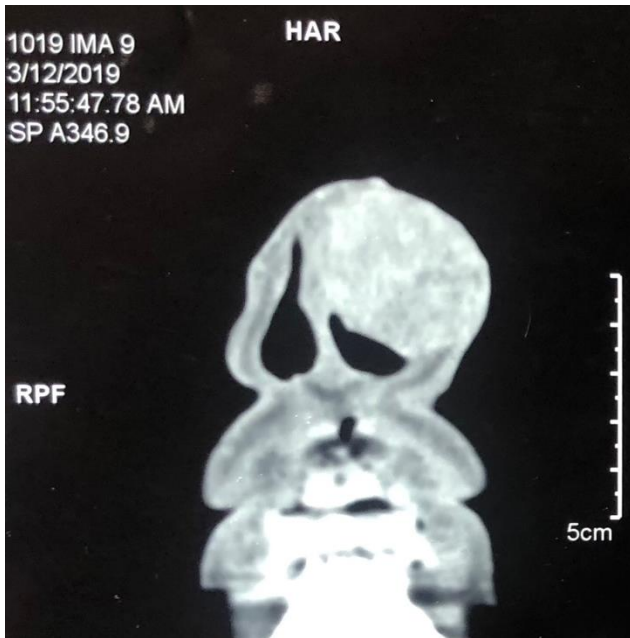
Axial cut of Contrast enhanced computed tomography of nose and paranasal sinuses.
